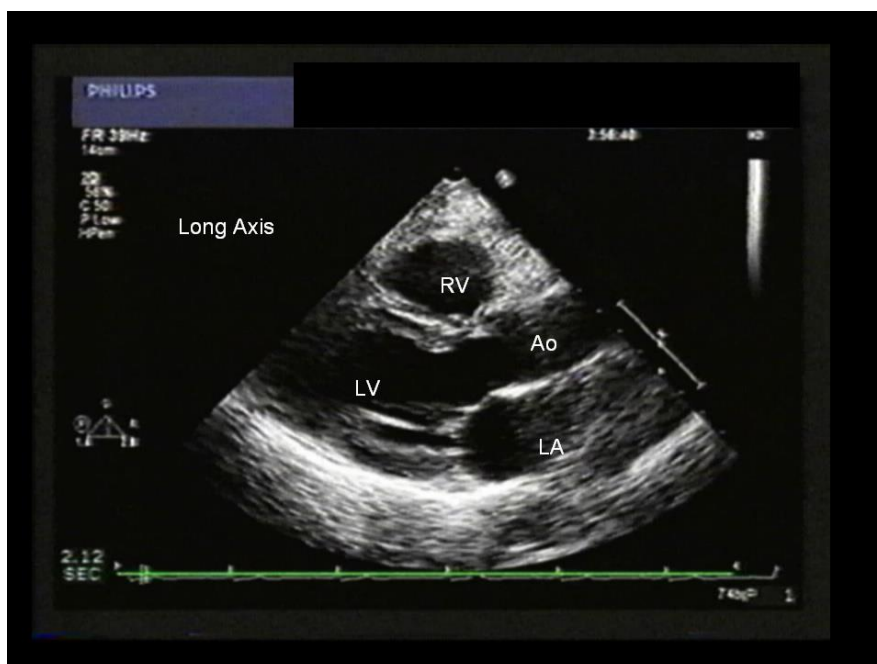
Parasternal long axis. RV, right ventricle; LV, left ventricle; Ao, aorta; LA, left atrium.
